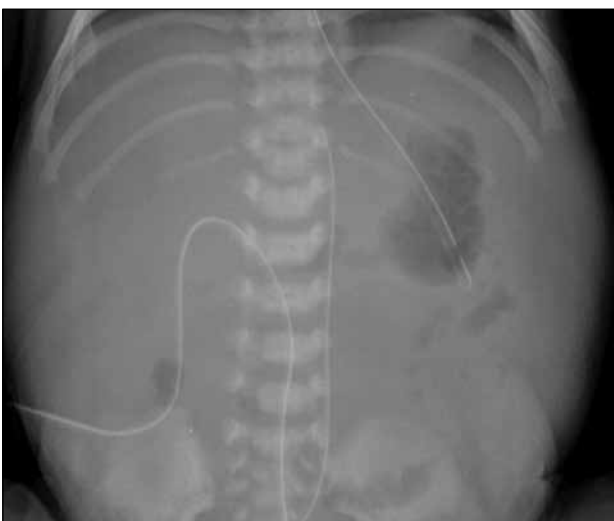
An abdominal radiograph after exchange transfusion showing abdominal distension is evident. The umbilical venous catheter tip is displaced inferiorly and to left of midline within the liver shadow, suggestive of an underlying mass effect in the right upper quadrant.
